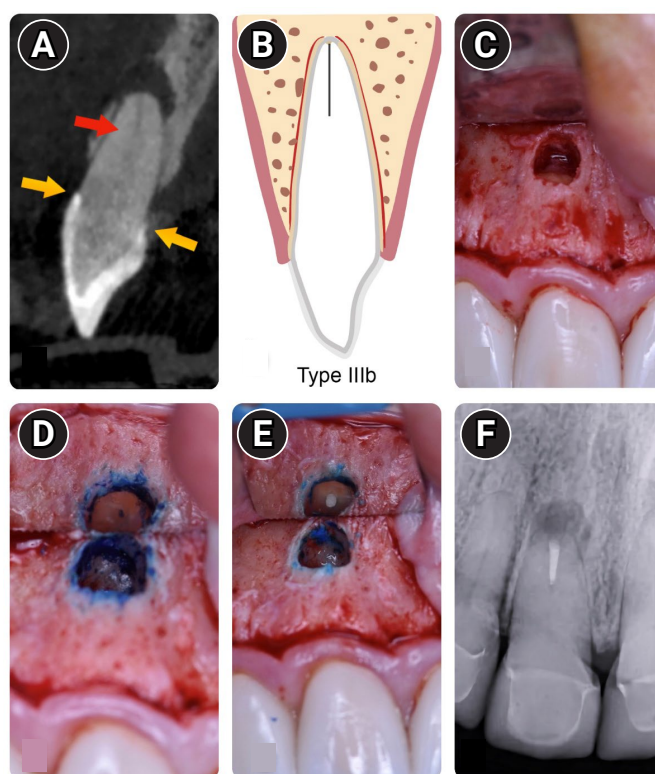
Characteristics of Type IIIb root canal classification. (A) Tomographic image, target point (red arrow), adapted crown (yellow arrows). (B) Type IIIb classification scheme. (C) Access to apex. (D) Root apex outline (methylene blue). (E) Filled root canal with the retrograde filling material. (F) Postoperative periapical radiograph showing root-end fillings.
